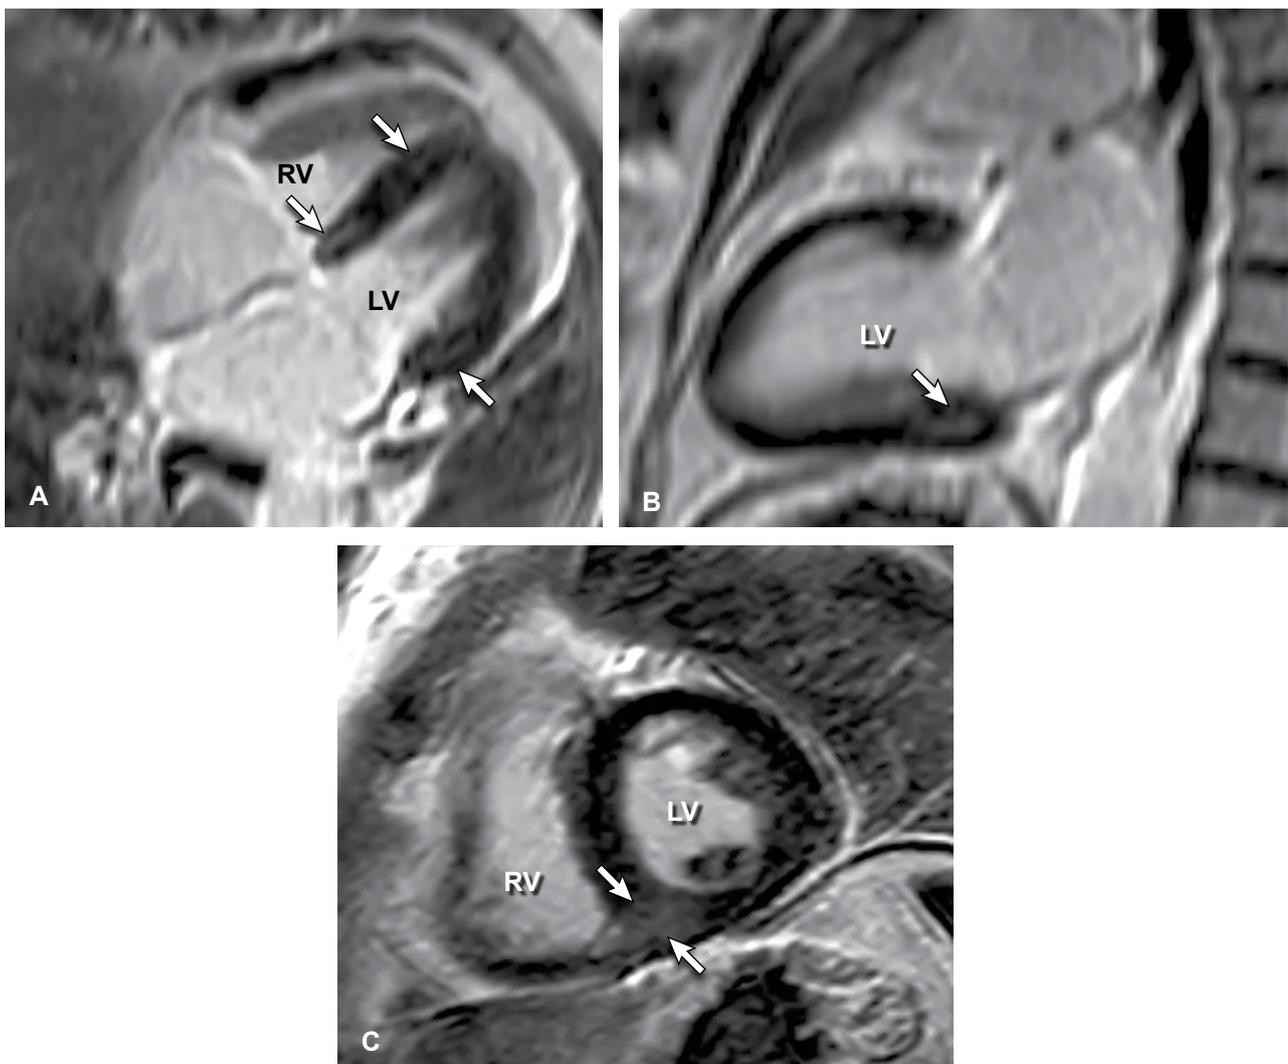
Representative delayed-enhanced magnetic resonance images in a patient with systemic sclerosis. A: Four-chamber view, showing relatively intense linear mid-wall enhancement (arrows) in the basal segments of the interventricular septum and free wall, as well as a focus of more subtle enhancement at the apical segment of the interventricular septum. B: Vertical long-axis view, showing linear mid-wall enhancement (arrow) in the basal segment of the inferior wall. C: Short-axis view, showing globular patchy enhancement with indistinct borders (arrows) at the lower RV insertion point. RV – right ventricle; LV – left ventricle. From reference 12. This material is reproduced with permission of John Wiley & Sons, Inc. © 2007 American College of Rheumatology.
